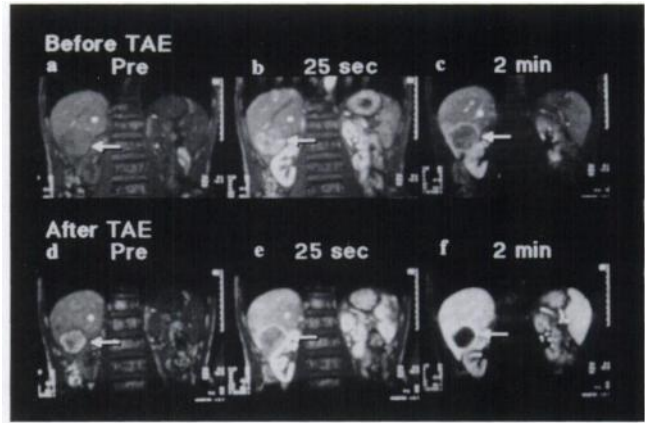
Data from a 70-yr-old male patient (Patient 5) pre- and post-transarterial embolization (TAE) of nodular hepatocellular carcinoma (HCC). Pre-TAE dynamic MRI (FL2D TR/TE/FA, 74/6/80) depicts the HCC as an area of increased arterial blood supply: (a) predynamic, (b) 25 sec and (c) 2 min. Post-TAE dynamic MRI (FL2D TR/TE/FA, 90/6/80) demonstrates no perfusion to the treated HCC: (d) predynamic, (e) 25 sec and (f) 2 min.
